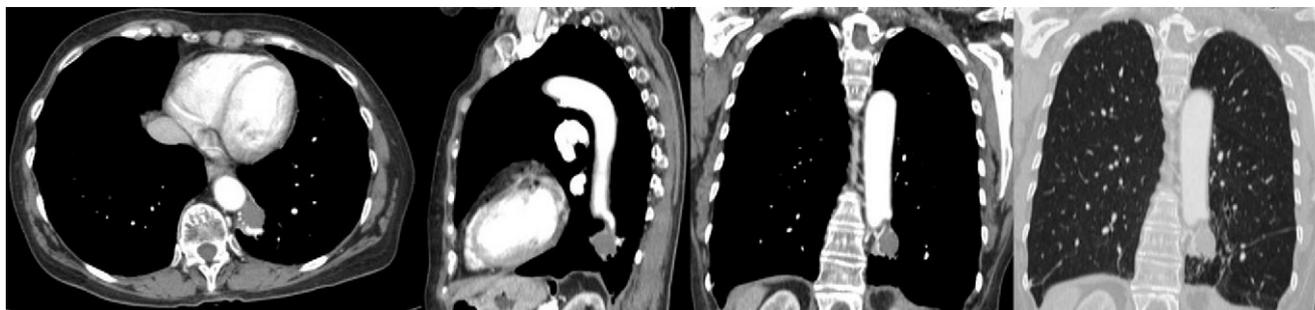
Computed tomography study with intravenous contrast.
